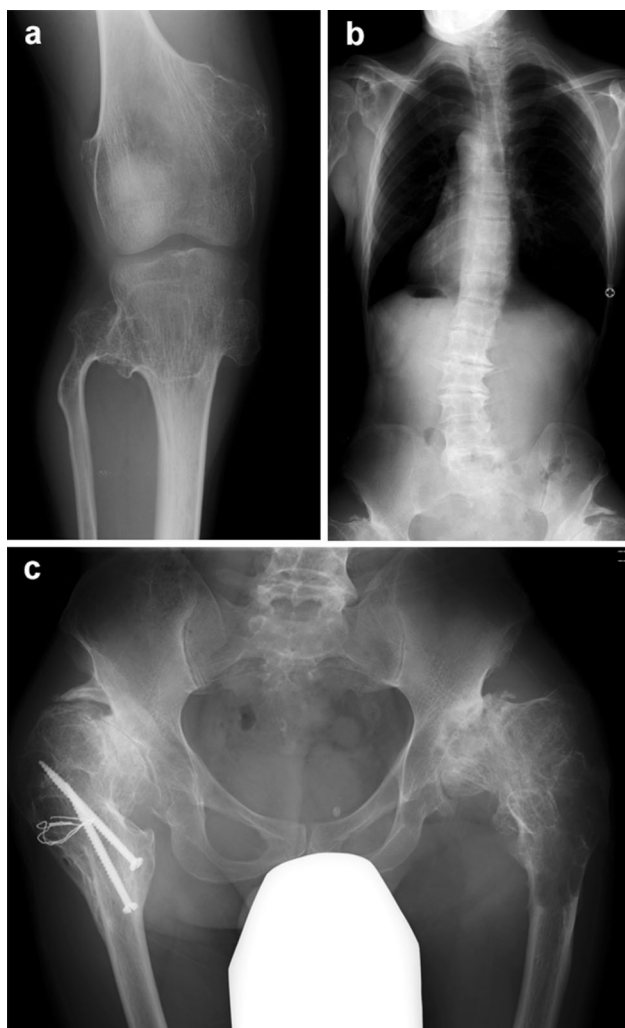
A 40-year-old male with MHE. a Multiple lesions in the lower extremities. b Scoliosis with a 22° curve that is convex to the left between L1 and L5. c AP pelvic radiograph. The patient initially underwent a varus proximal femoral osteotomy of his left hip, accompanied by right valgus femoral osteotomy for bilateral coxa valga with bilateral acetabular dysplasia
